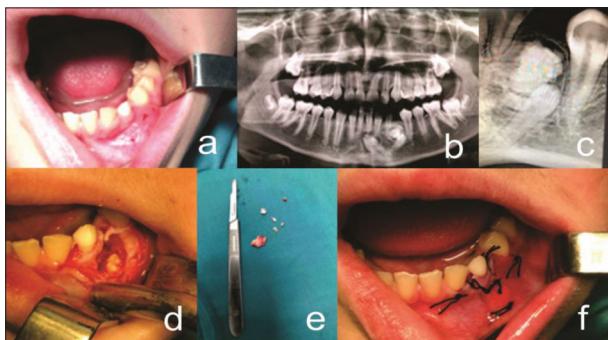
Persistence of the tooth 73 (a – clinical appearance, b – X-ray, c – X-ray, d – extraction site, e – extracted supernumerary tooth, f – post extraction suture)
